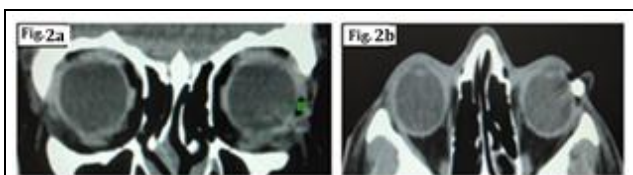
Coronal Reformatted CT Scan of the Orbits Reveals a Soft Tissue Density Lesion with Fat in the Supero-Temporal Quadrant of Left Eye. Figure 2b. Axial CT Scan Shows a Focal Calcification in the Lesion which is not Continuous with the Epibulbar Fat
